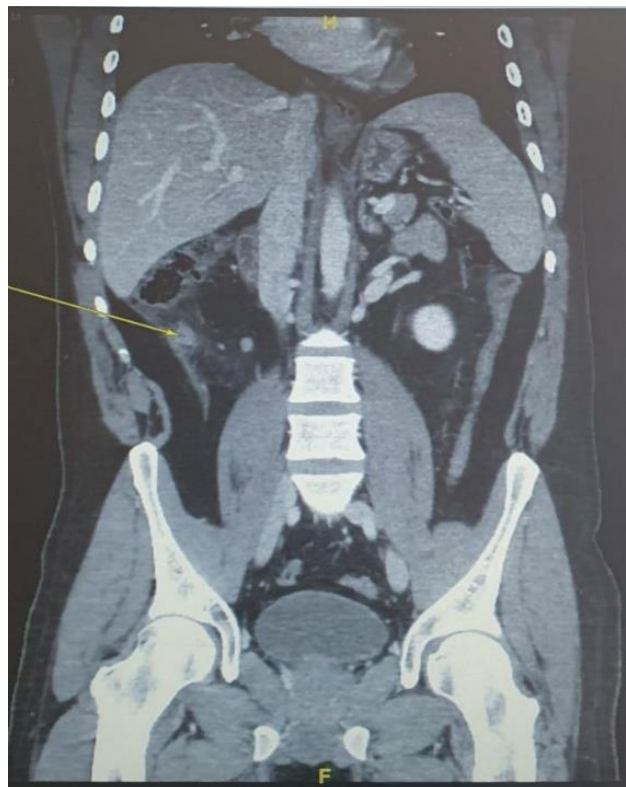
Coronal view of pre op CT abdomen showing acutely inflamed appendix
